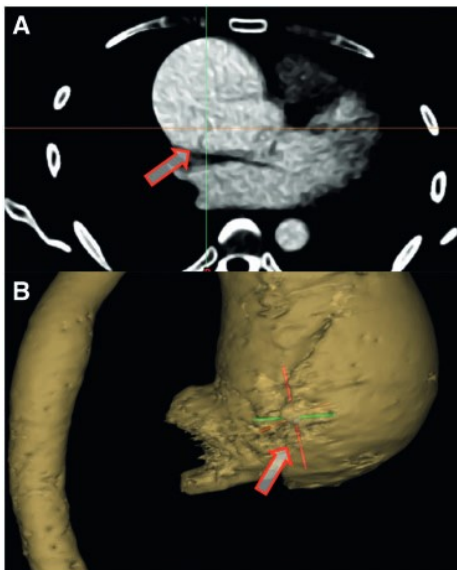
Computed tomography study determining the site of the intimal tear.
